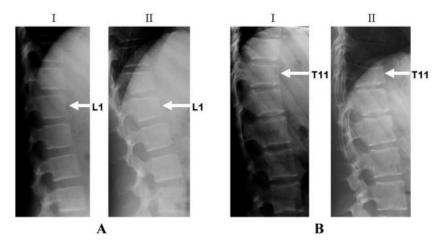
Examples of incident vertebral fracture at 12 months. A (I) shows a normal spine radiograph at study entry (within 30 days of glucocorticoid initiation) in an 11-year-old girl with systemic lupus erythematosus. At 12 months (II), this child manifested a grade 1 incident vertebral fracture at L1. B (I) shows a normal spine radiograph at study entry in a 16-year-old girl with systemic lupus erythematosus. At 12 months (II), this child was identified as having a grade 2 incident vertebral fracture at T1.
